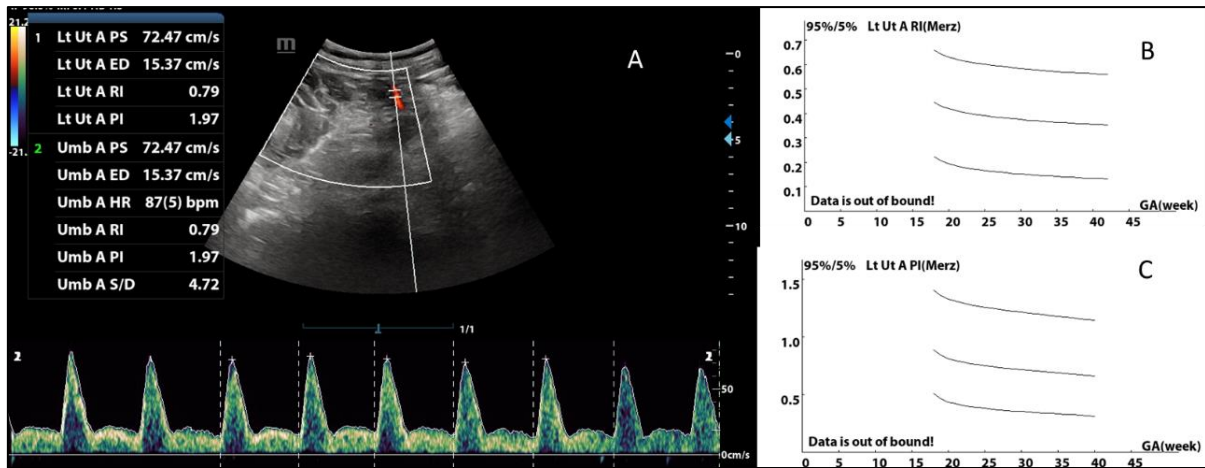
Left uterine artery color and spectral Doppler [A], showing early diastolic notching, [B]. very high resistance index [RI-0.79] above 95<sup>th</sup> percentile and beyond the limit of 0.79 and C) very high pulsatility index [PI-1.97] above 95<sup>th</sup> percentile per age and beyond the limit of 1.5
